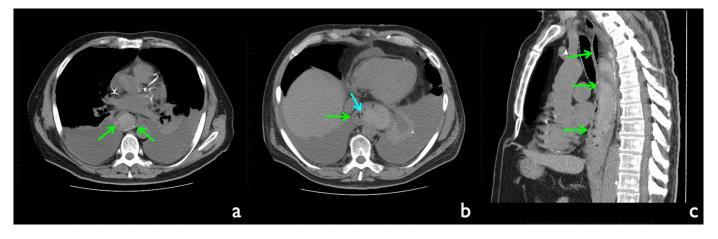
73-year-old man with resolving intramural esophageal hematoma. (a) Axial non-contrast CT of the chest demonstrates a high attenuation mass measuring 3.5 x 4.8 x 19.2 cm (AP x TR x CC) in the proximal esophagus consistent with an esophageal hematoma (green arrows). (b) Axial non-contrast CT of the chest demonstrates a high attenuation mass in the distal esophagus (green arrow). Air fluid levels within the esophageal lumen suggest an intramural location of the hematoma (blue arrow). Note the decrease in size in comparison to Figure 3. (c) Para-sagittal non-contrast CT of the chest demonstrates the extension of the high attenuation mass along the mid to distal esophagus (green arrows). Note the decrease in affected length and presence of air fluid levels compared to Figure 3. (Protocol: 436 mA, 120 kVp, 5.0 mm thickness)
